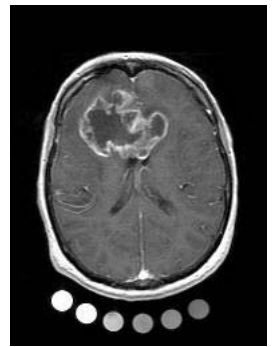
Postcontrast brain MR image with a multiform glioblastoma from T1 dynamic series.
